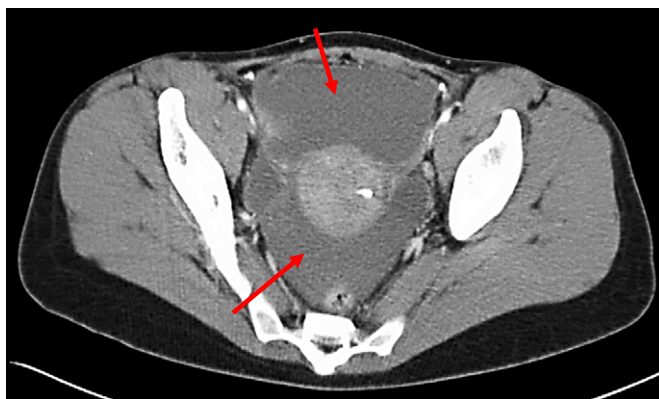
CT of the pelvis (axial view) showing free fluid in the pelvis.
